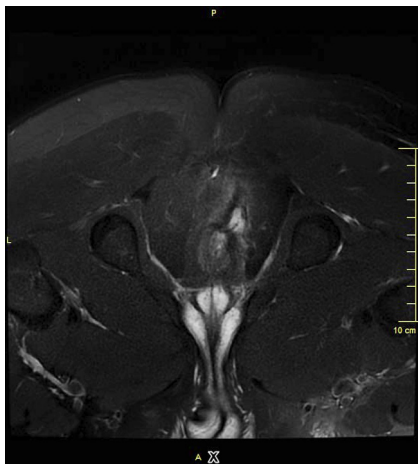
Axial T2-weighted image with fat suppression showing high lying trans-sphincteric fistula near anorectal junction at 7 o'clock position.
